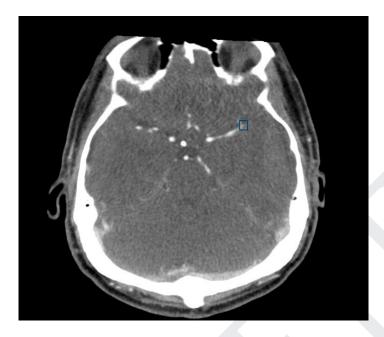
Example of StrokeViewer LVO output. Detected LVO location is highlighted with a blue bounding box on the CTA scan.
